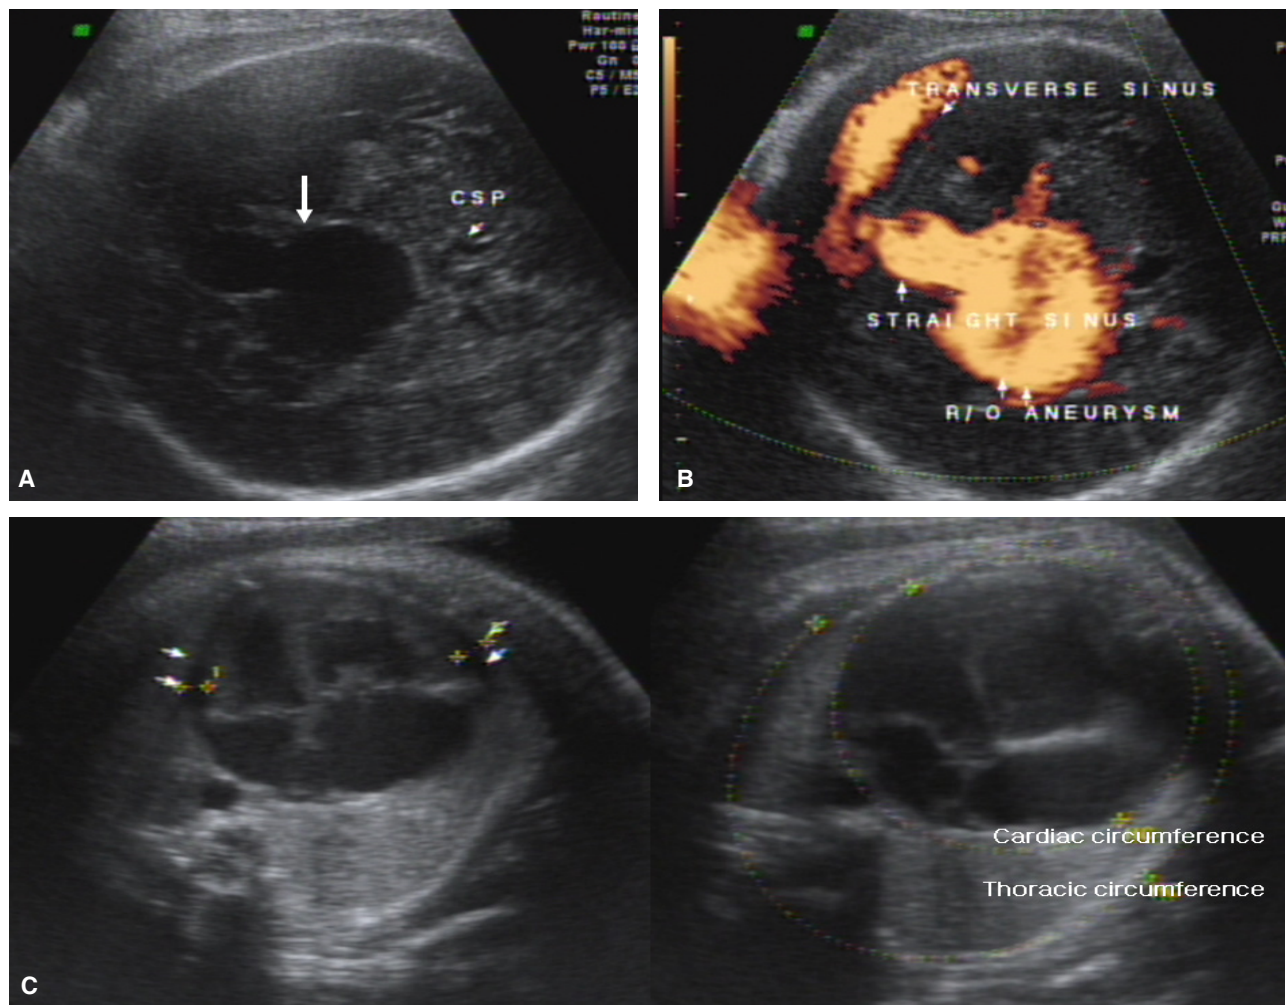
Two-dimensional Ultrasound images at 37⁺⁴ weeks of gestation. (A) Intracranial vascular mass measuring in 3.2×3.2 cm. (B) Doppler imaging showing a turbulent flow and a blood draining into an enlarged straight sinus, suggesting a vein of Galen aneurysm. (C) Severe cardiomegaly with pericardial effusion, reflecting an advanced fetal congestive heart failure (left). Cardiac circumference/thoracic circumference ratio (cardiothoracic ratio) of 73% (right).
